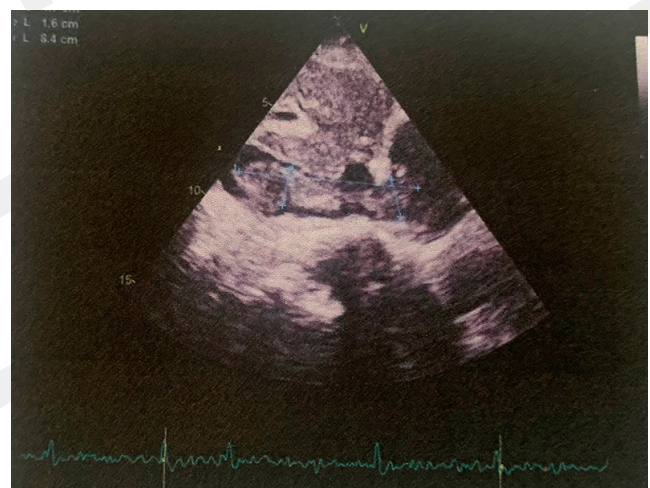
Echocardiography performed at pre-hospital diagnosis, visible thrombus in VC
